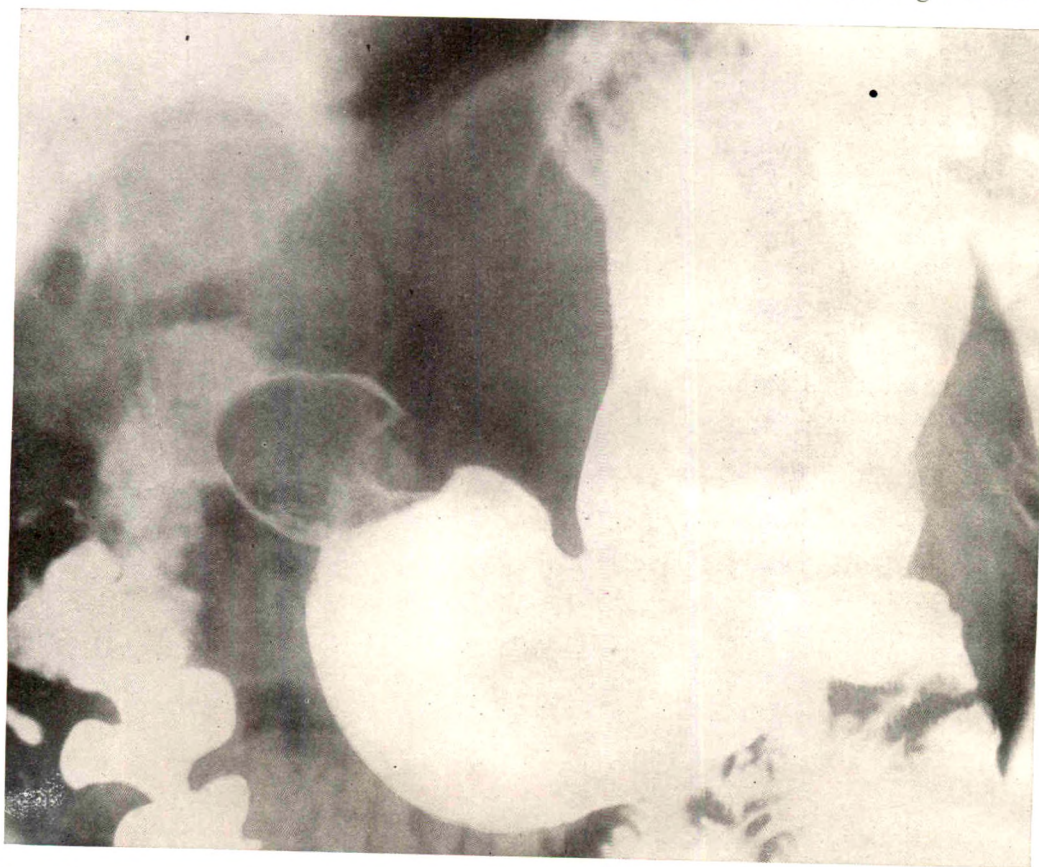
Roentgenogram showing clear-cut marginal outlines of the empty duodenal bulb. Note that the multilocular appearance of the bulb is still maintained.
